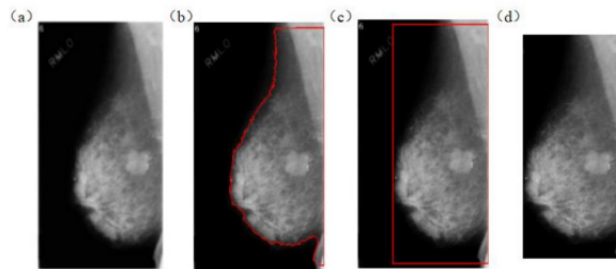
Segmentation effect of breast X-ray image: (a) original breast image; (b) Breast contour; (c) Box interception; (d) Breast extraction<sup>[11]</sup>
